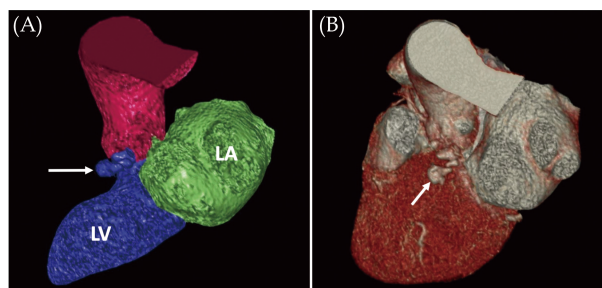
Colored volume rendered (A) and 3-D reconstruction (B) cardiac computed tomography demonstrating the subaortic pseudoaneurysm (arrows). LA: left ventricle, LV: left ventricle.
